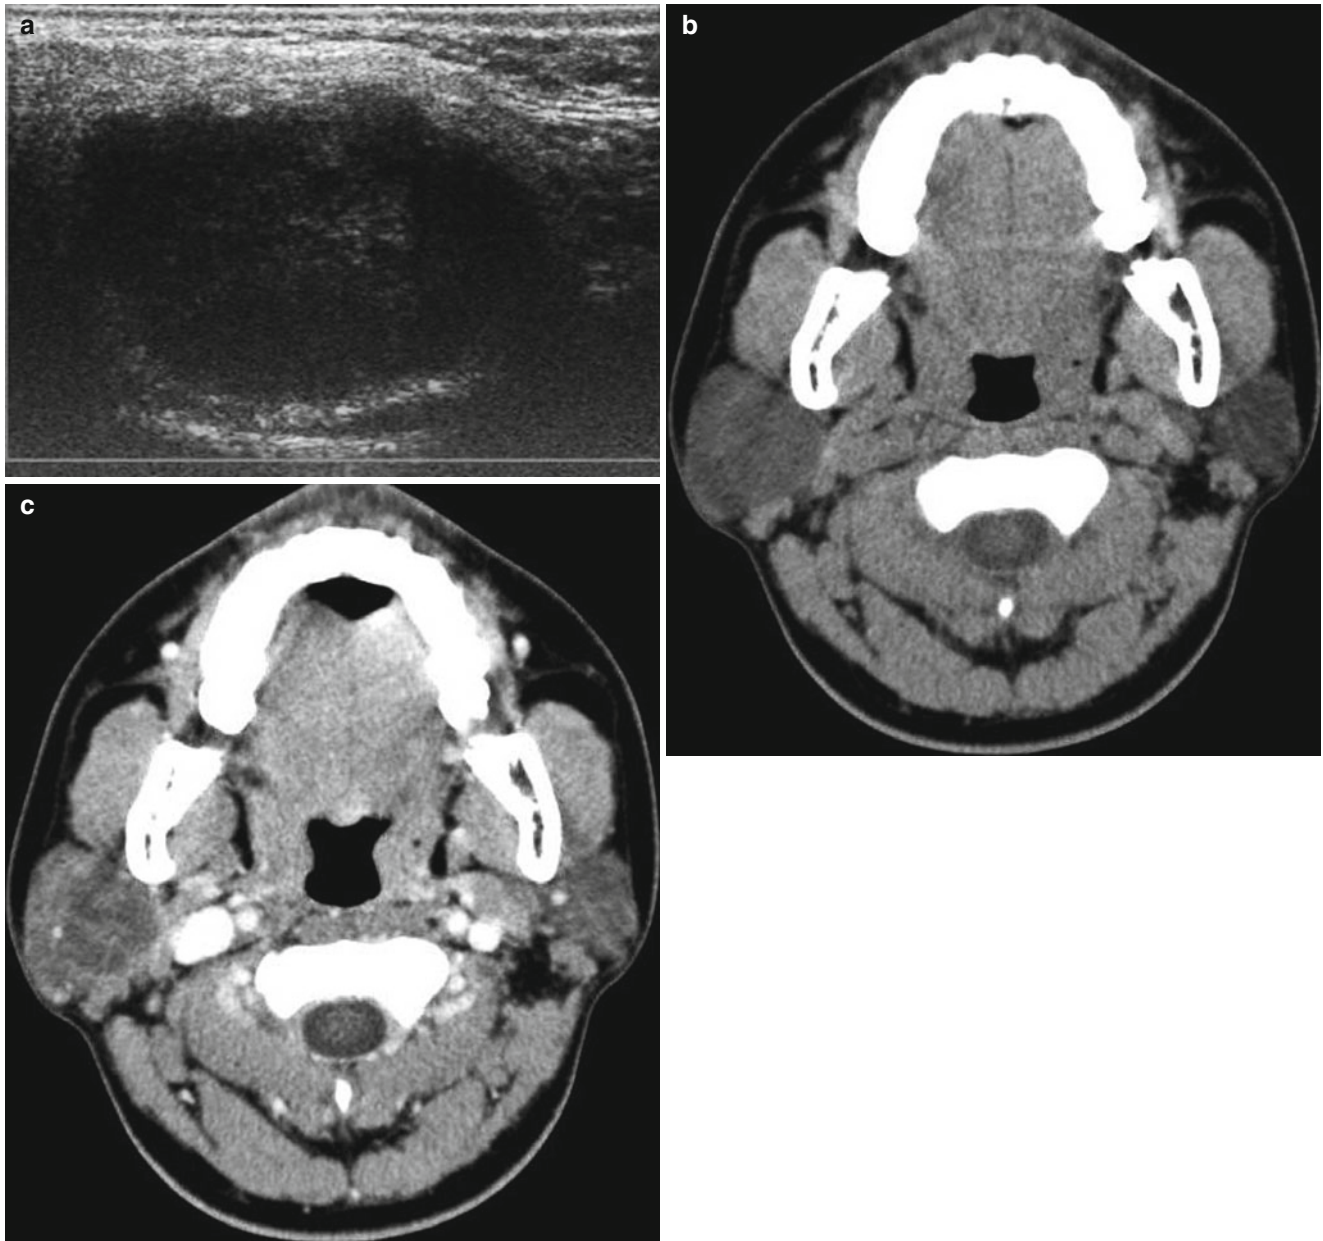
Pleomorphic adenoma in a 13-year-old boy. (a) Color Doppler US shows a lobulating, hypoechoic, and hypovascular solid mass in the right parotid gland. (b) Nonenhanced CT scans shows an
